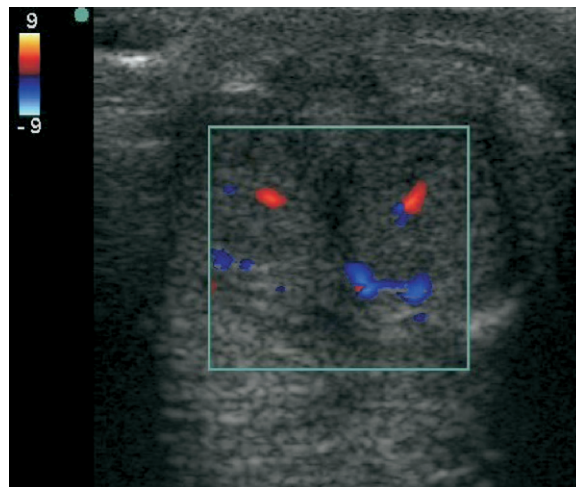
Color Doppler ultrasound of penis posttreatment. Used with permission of Eric B. Tomich, DO, Department of Emergency Medicine, Madigan Army Medical Center, Tacoma, WA.
